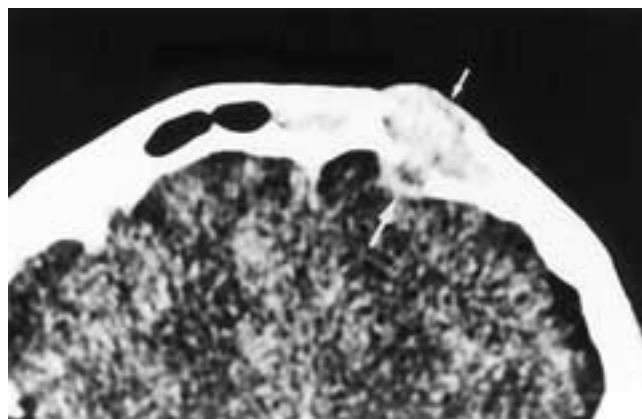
Axial CT scan shows an enhancing mass in the left frontal sinus that has eroded both the anterior (*small arrow*) and posterior (*large arrow*) sinus walls. This patient had a rare frontal sinus squamous cell carcinoma.
